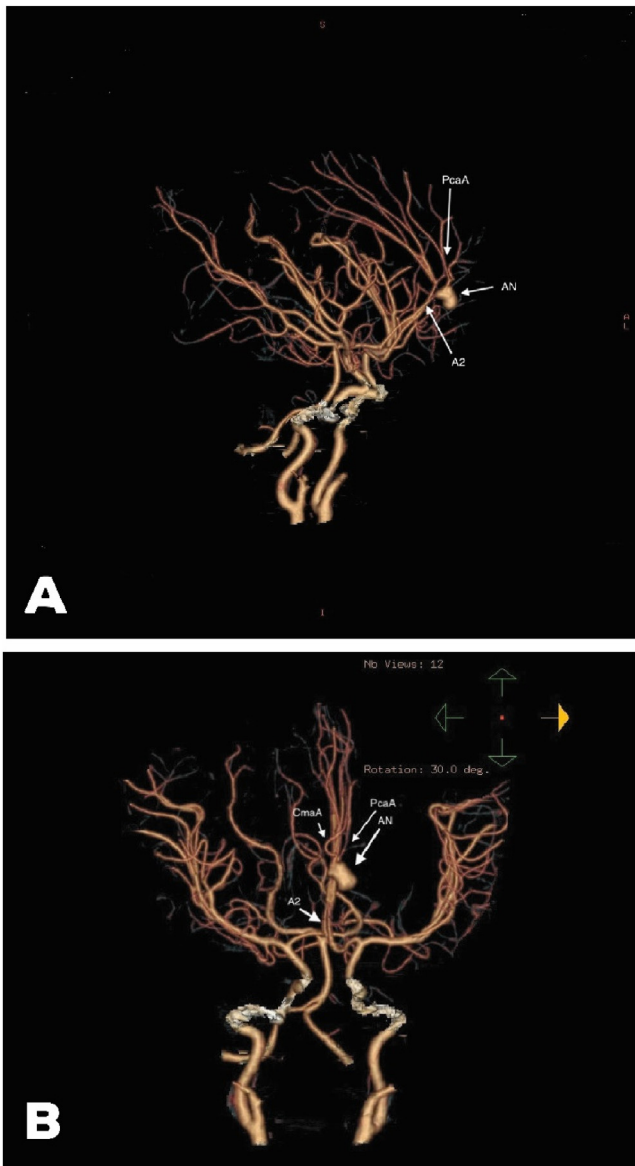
A,B: The CT angiography showed an aneurysm in distal ACA. PcaA: Pericallosal artery. CmaA: Callosal marginal artery. AN: Aneurysm. A2: A2 segment of ACA.
